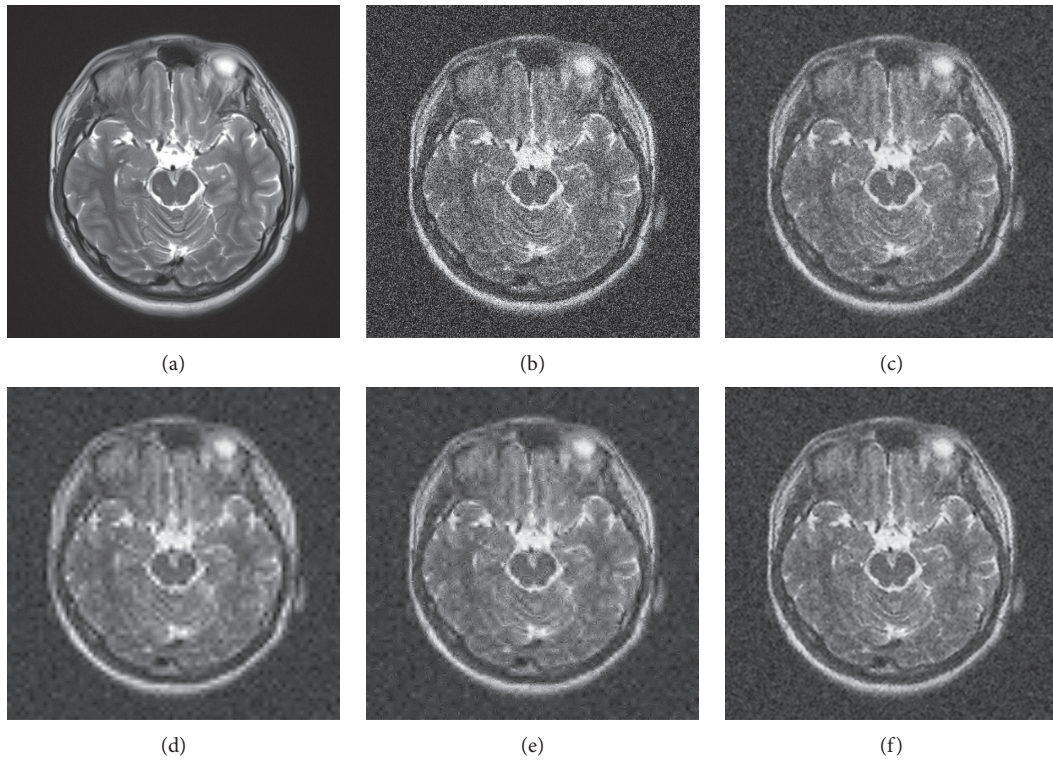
Subjective denoising results of MRI 2 in different ways. (a) Original image, (b) noisy image, (c) Wiener filter, (d) hard threshold, (e) soft threshold, and (f) proposed.
